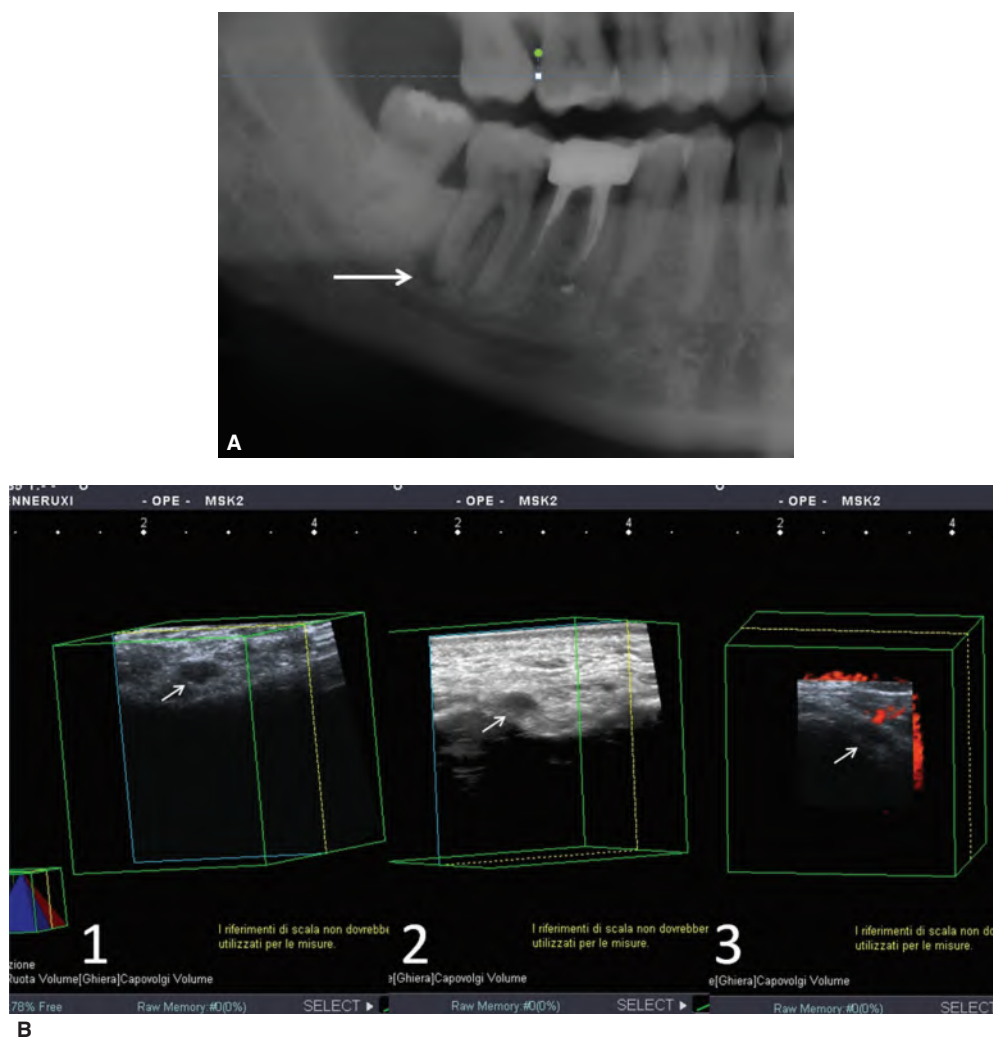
10 Three-dimensional (3-D) ultrasonic imaging of a periapical lesion in the mandible. A. Detail from the panoramic radiograph showing the presence of apical periodontitis on the distal root of the mandibular second molar (arrow). B. 3-D ecographic examination of the lesion disclosing an hypoechoic appearance and the presence of vascularity (periapical granuloma): (1) regular 3-D image (arrow); (2) 3-D subtraction image of the same lesion (arrow); (3) 3-D image with echo-CPD of the same lesion showing the vascular supply (arrow).
